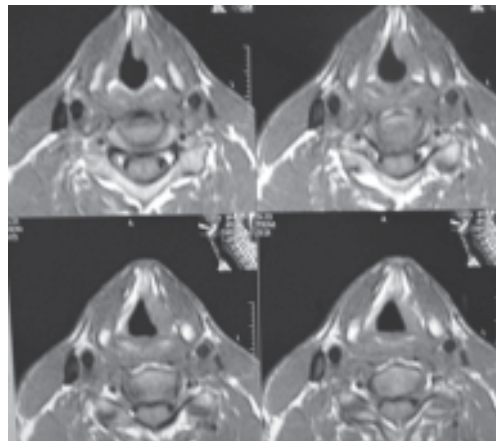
MRI of larynx showing isointense shadow involving left side of larynx.
